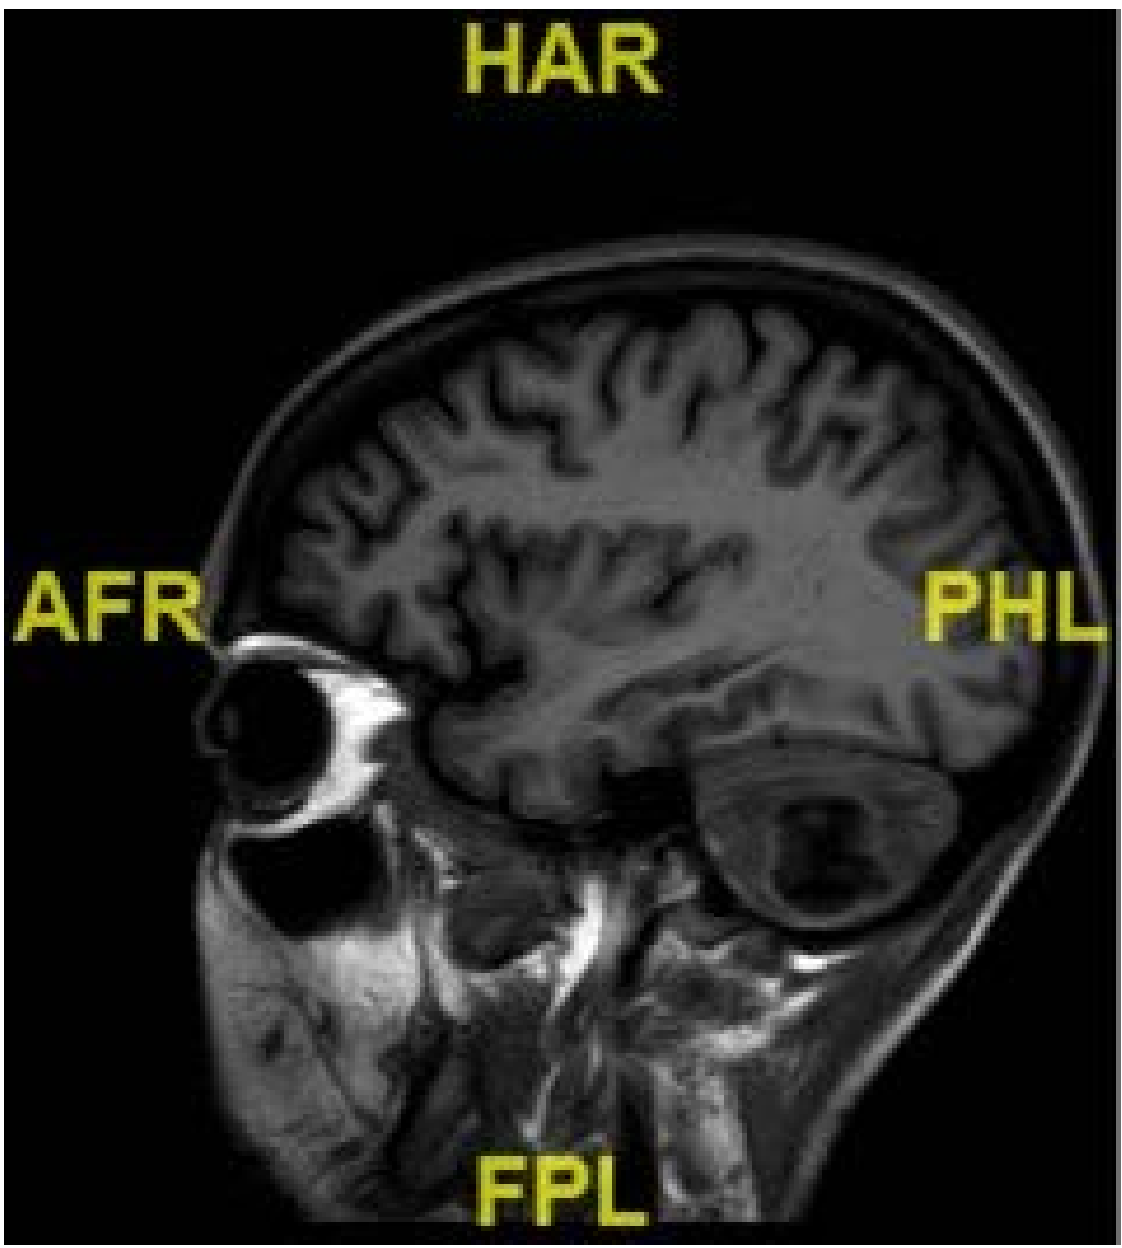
Sagittal brain MRI without contrast showing cerebellar abscess (sagittal view).
